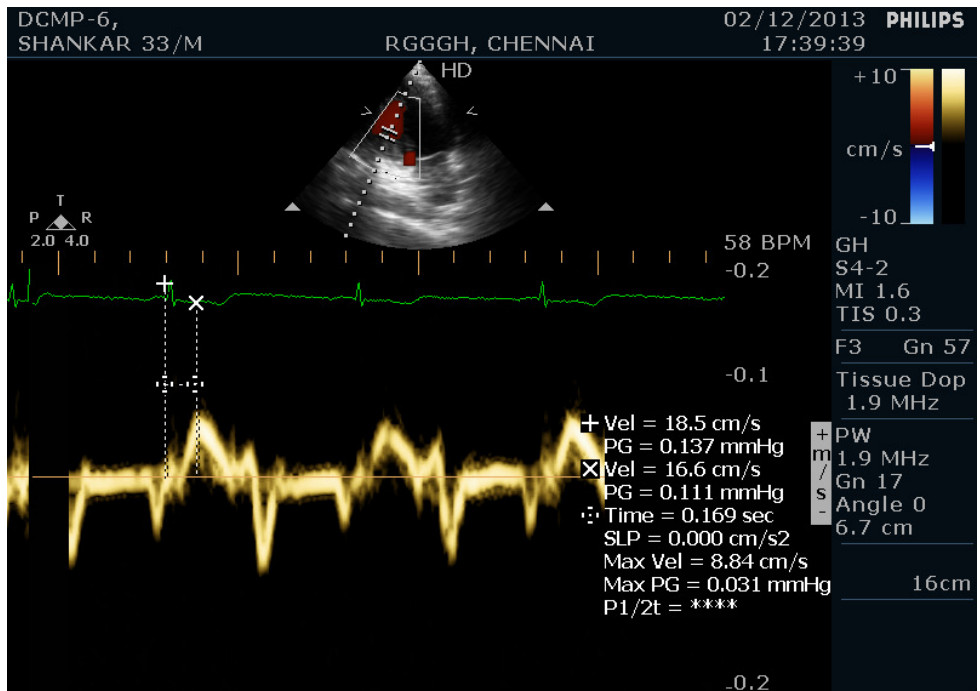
Measurement of Ts of mid inferior wall in apical 2 chamber view using tissue Doppler imaging.
